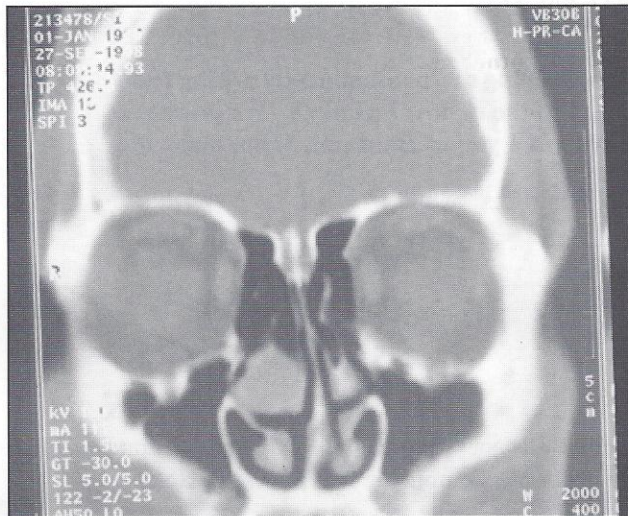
Coronal CT scan of the paranasal sinuses showing mucocele the middle turbinate.
